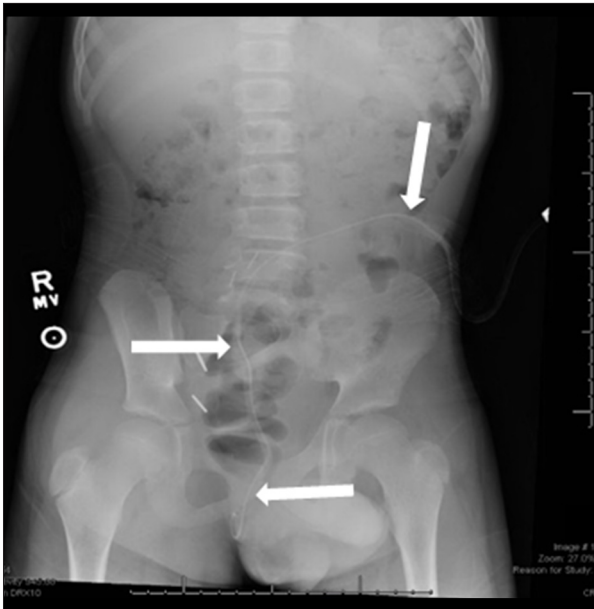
Abdominal X-ray anteroposterior view showing PD catheter with the tip projecting over the perineum (arrows).
